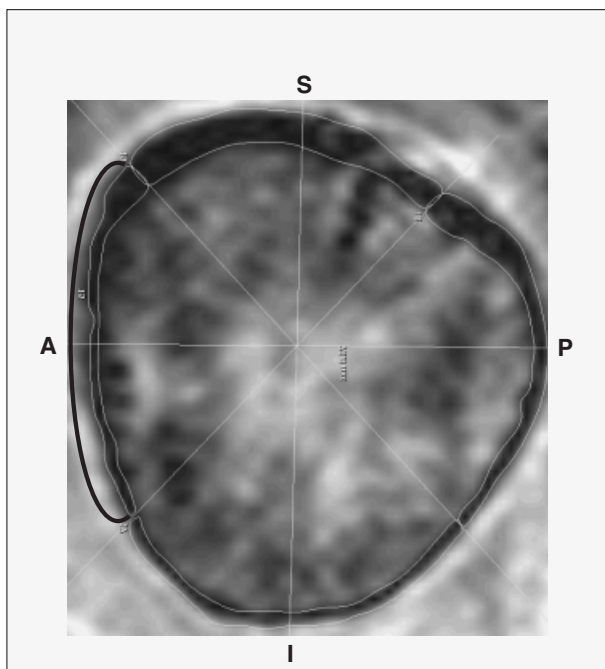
Magnetic resonance image of the femoral neck cross-section at its narrowest location. Periosteal and endosteal cortical boundaries and the cortical quadrants are indicated.
